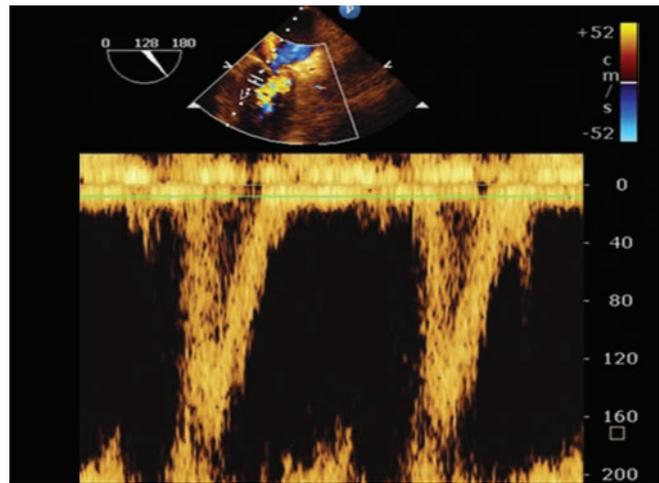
TEE Pulse wave Doppler. Shows mitral in flow pattern.
